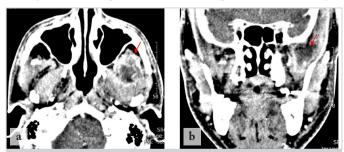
Preoperative CT scans: a. Axial CT view showing the clear borders of a 21x19 mm abscess in the left infratemporal fossa along the temporalis muscle with surrounding edema and inflammatory changes. b. Coronal CT view of the left infratemporal fossa abscess CT: Computed tomography
